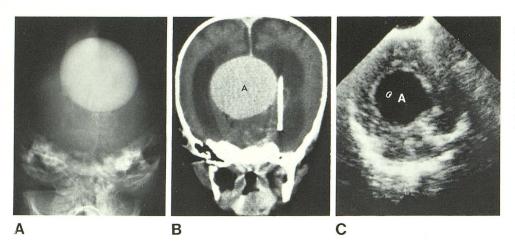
A, Frontal view, vertebral angiogram. Large aneurysm. B, Coronal CT scan after intravenous contrast enhancement. Large vein of Galen aneurysm (A) splaying apart enlarged lateral ventricles. Shunt tube in right lateral ventricle. C, Coronal sonogram through anterior fontanelle. Aneurysm (A) is seen as large cystic space within central part of brain. No evidence of hydrocephalus at this time.
